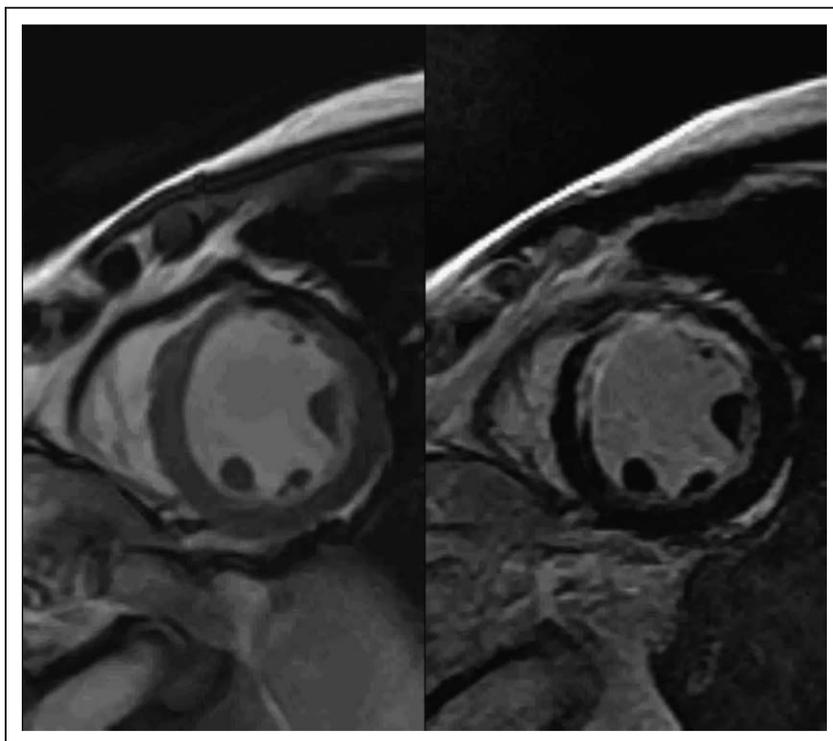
Cardiovascular magnetic resonance imaging of a patient with a chronic anterior infarction.
